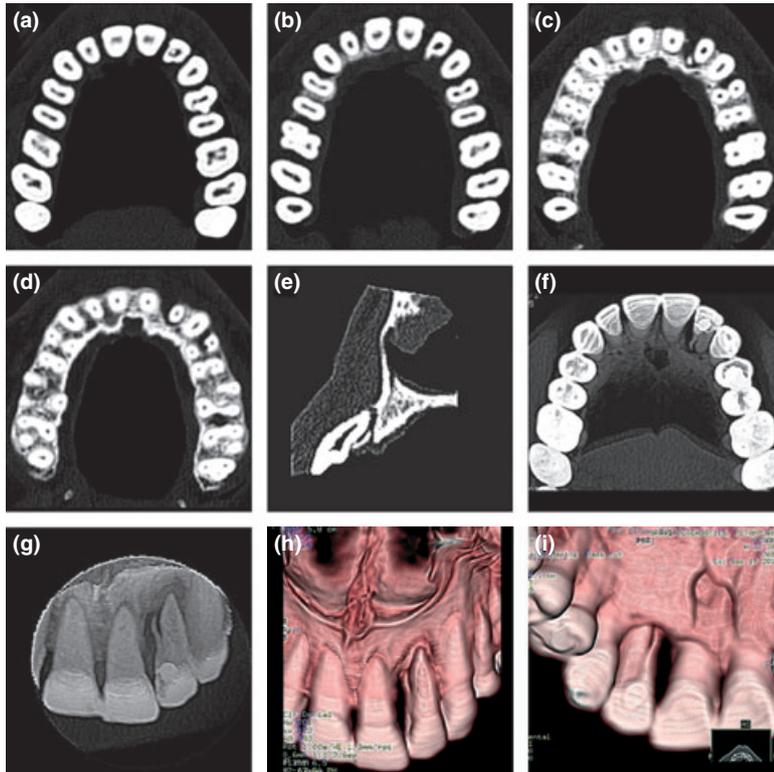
Spiral computed tomography images of the maxilla. (a) Axial view of the coronal third section of the crown of tooth 22. (b) Axial view of the cervical third section of the roots of tooth 22. (c) Axial view of the middle third section of the roots of tooth 22. (d) Axial view of the apical third section of the root of tooth 22. (e) Cross-sectional image. (f) Occlusal scan section. (g) Antero-posterior view. (h, i) 3D reconstruction of the two rooted maxillary lateral incisor.
